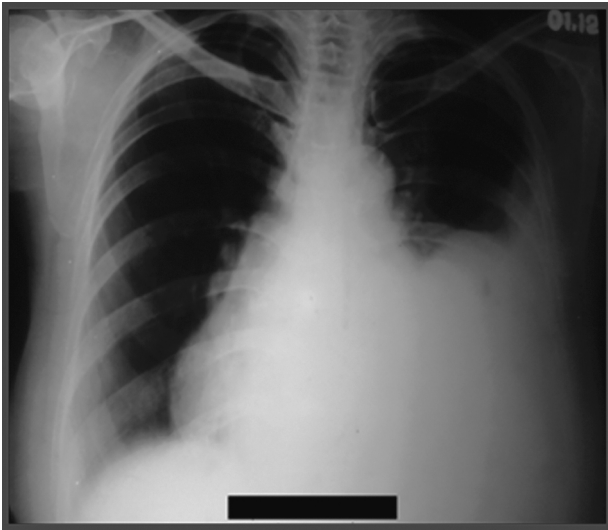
Chest radiograph (postero-anterior view) showing moderate left sided pleural effusion with a somewhat upward convexity.
